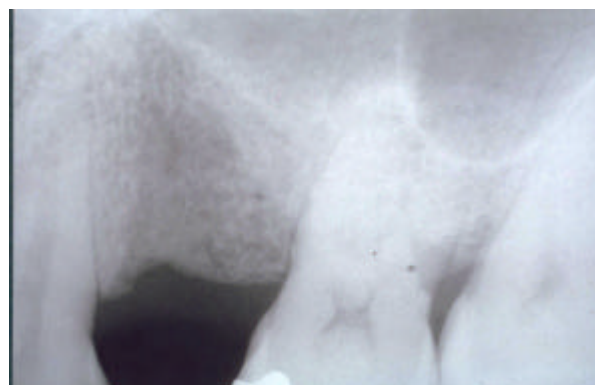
Intra-oral X-ray of the site after 8 months. Here the formation of the neoformed bone is almost completed and it has progressed to the coronal region.
